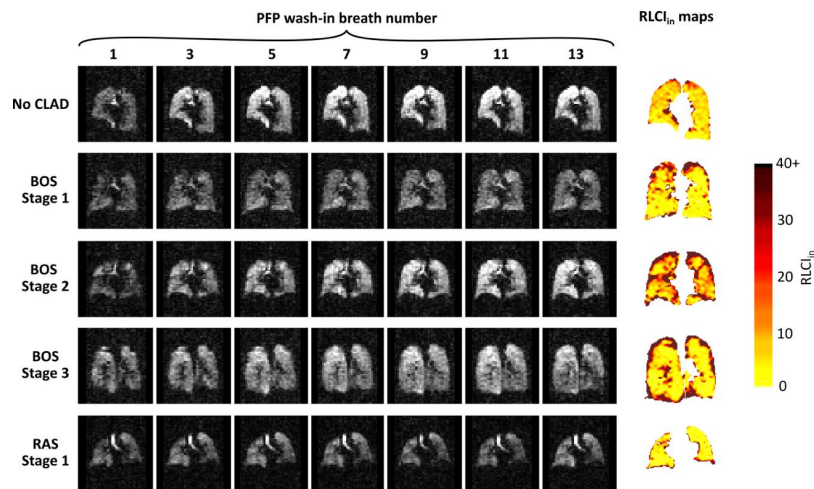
The central coronal slice through 3D ^{19}F -MRI images of inhaled PFP in five representative participants. Images were taken during consecutive breath holds to capture PFP gas wash-in. The corresponding central slice of the resultant 3D RLCI map is displayed in colour.
